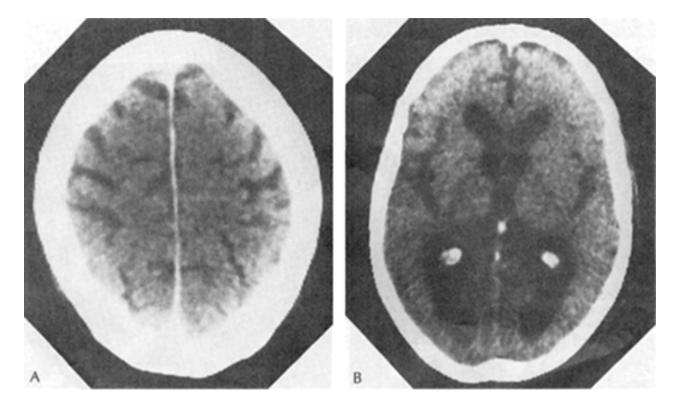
Brain CT scans. Marked ventricular dilatation (A) and widening of cortical sulci (B) indicative of hydrocephalus ex vacuo in a 64-year-old woman with dementia. (Reprinted with permission from Rowland LP, editor: *Merritt's Textbook of Neurology*, ed 9. Williams & Wilkins, 1995.)
